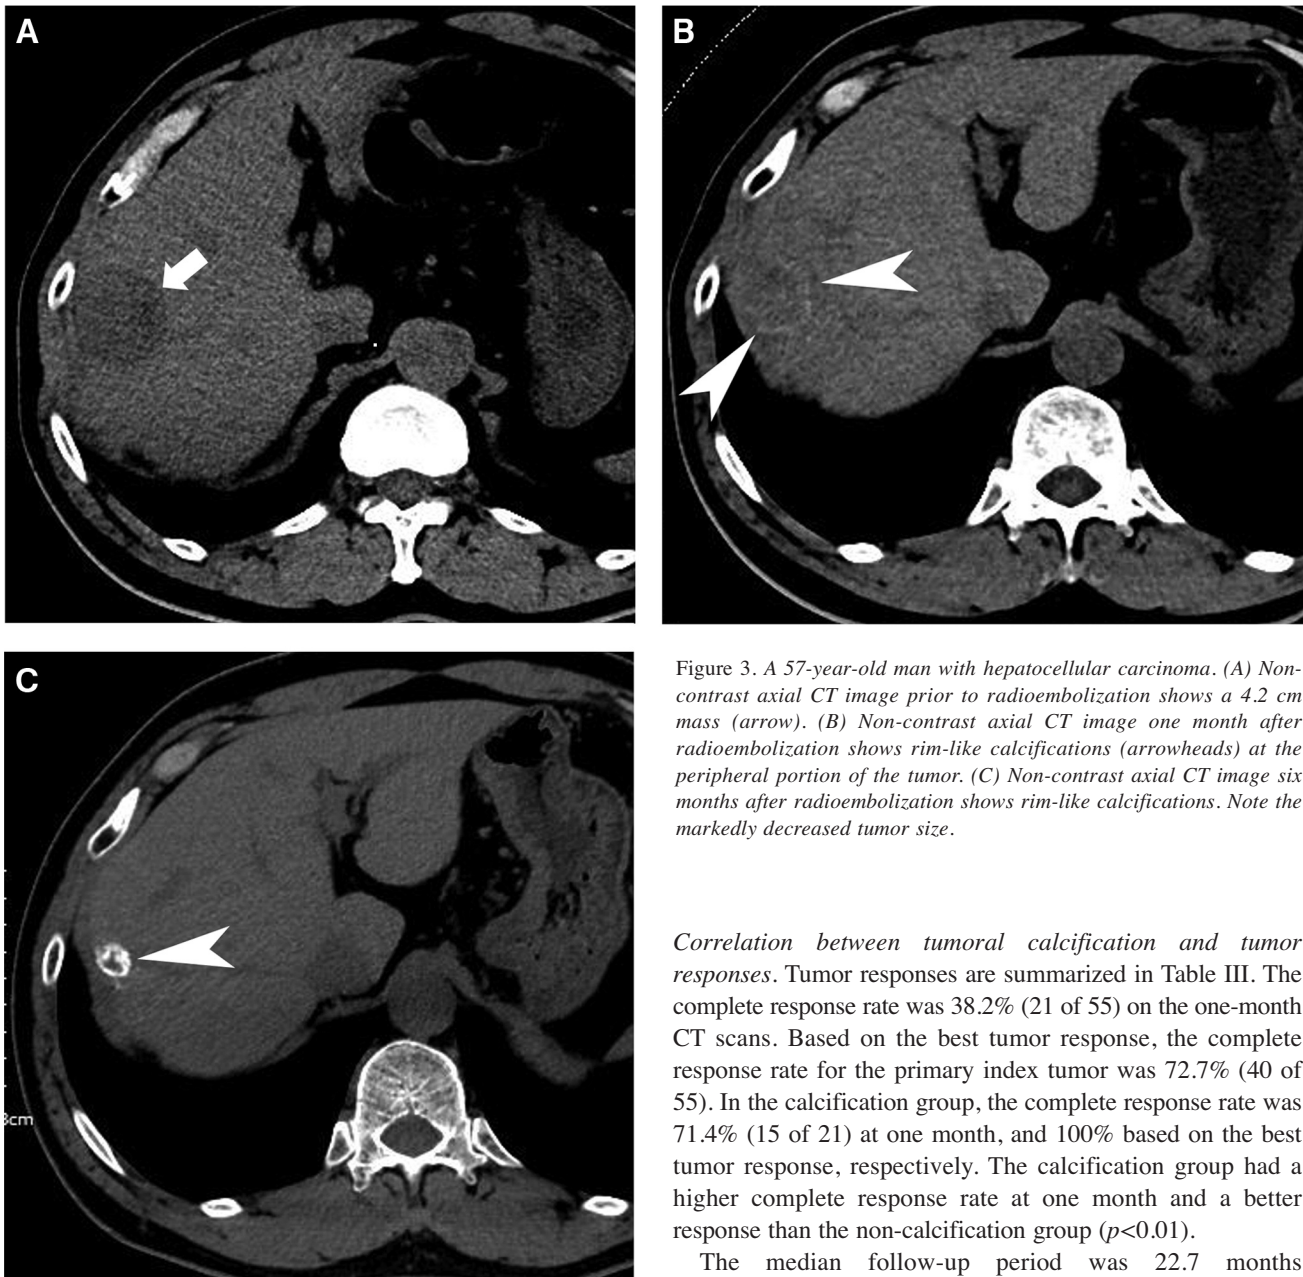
A 57-year-old man with hepatocellular carcinoma. (A) Non-contrast axial CT image prior to radioembolization shows a 4.2 cm mass (arrow). (B) Non-contrast axial CT image one month after radioembolization shows rim-like calcifications (arrowheads) at the peripheral portion of the tumor. (C) Non-contrast axial CT image six months after radioembolization shows rim-like calcifications. Note the markedly decreased tumor size.
